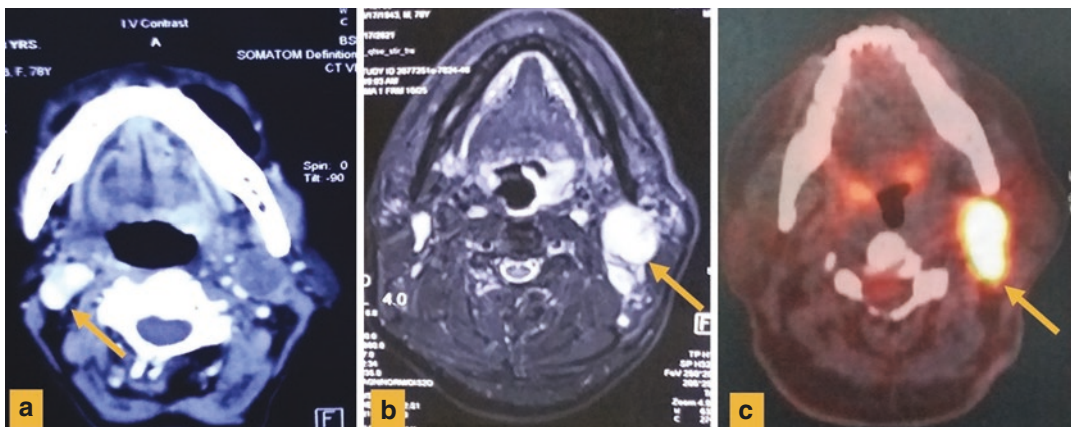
(a–c) Cervical lymph node metastasis in different patients: (a) CT scan, (b) MR T2W1, and (c) PET/CT
